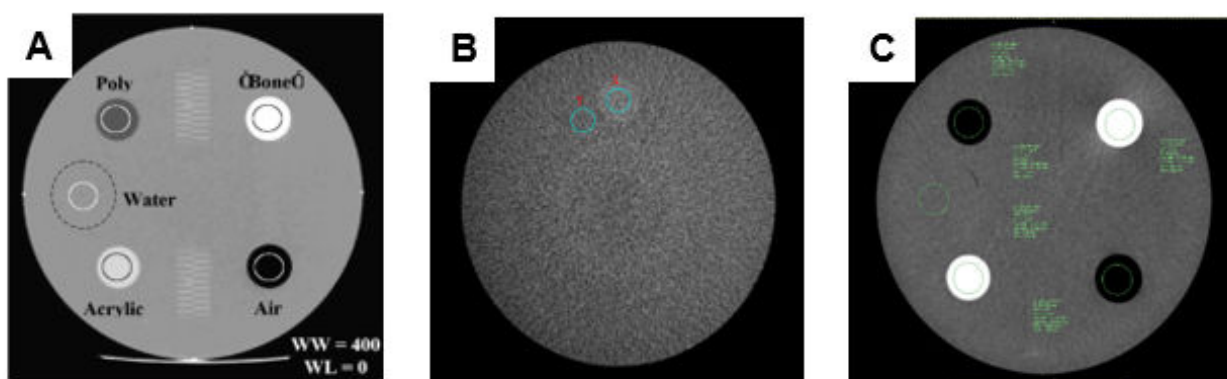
(A) Regions of interest (ROIs) for four materials, polyethylene, bone, air and acrylic and the water-equivalent background material; (B) Module 2 low contrast resolution image at WW, 100 and WL, 100 with correct ROI placements at X, signal, and Y, background; (C) CT number measurement of 4 materials and the water-equivalent background material.
